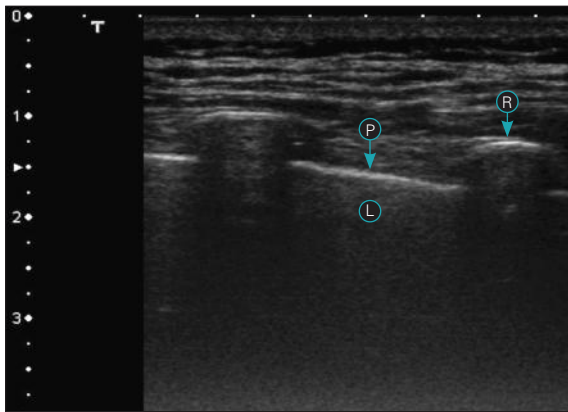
Pleural ultrasound showing echogenic reflection of the ultrasound wave from the rib (R) and pleural–lung interface. P = pleura, L = lung.
